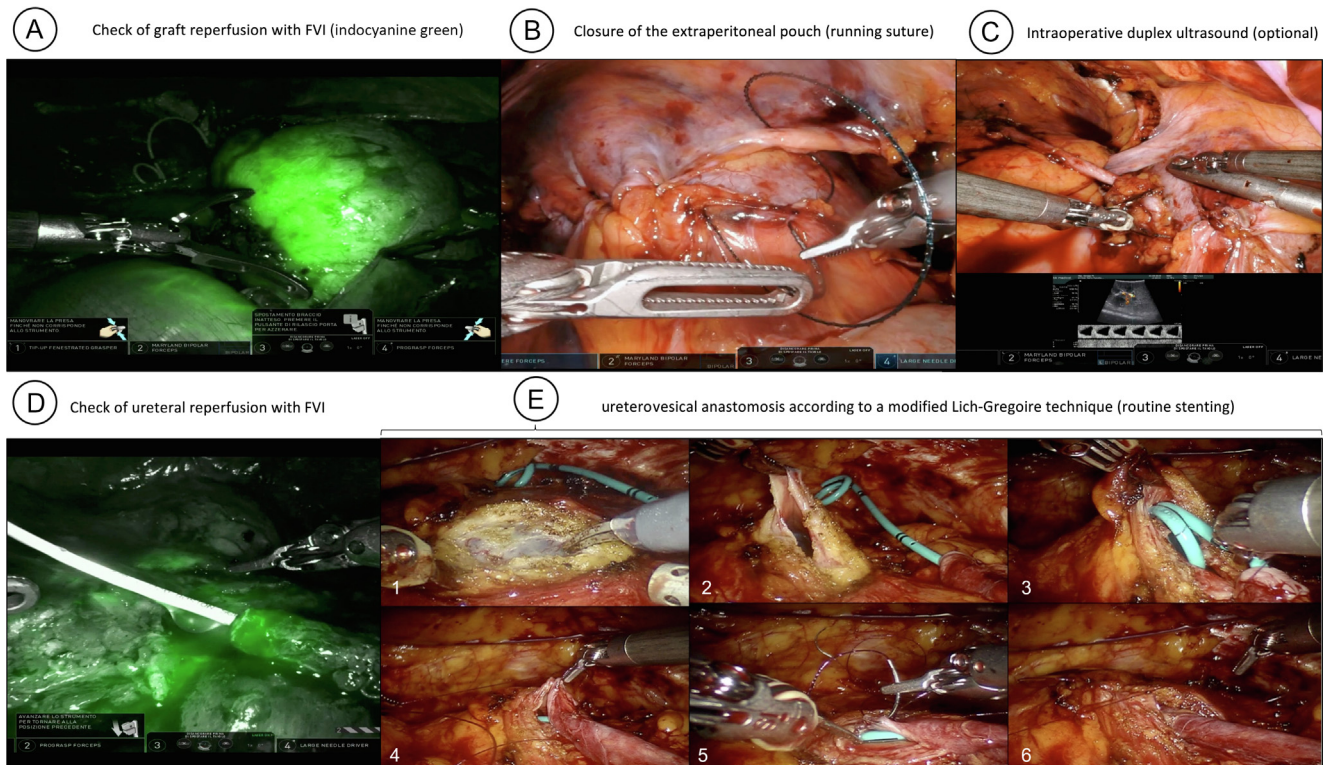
Intraoperative snapshots showing the last operative steps of robot-assisted kidney transplantation (RAKT) from donors after brain death (DBDs) according to the University of Florence technique. After completion of the vascular anastomosis, (A) the graft reperfusion is checked using intraoperative fluorescence vascular imaging with indocyanine green. Then, (B) the previously prepared extraperitoneal pouch is closed with a running suture. (C) Intraoperative duplex ultrasound may be used to further check graft reperfusion. (D) Before the ureterovesical anastomosis, the ureteral reperfusion is checked using intraoperative fluorescence vascular imaging with indocyanine green. Then, (E) the ureterovesical anastomosis is completed with two running absorbable sutures according to a modified Lich-Gregoire technique over the preplaced double-J stent (steps 1–6). FVI = fluorescence vascular imaging.
